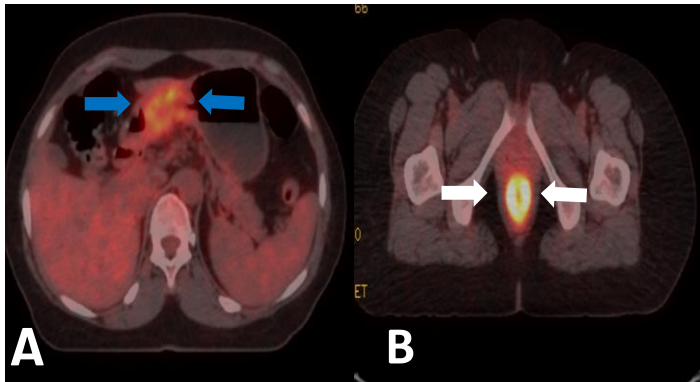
In the PET-CT axial and coronal sections, it is seen that radionuclide material is more intensely uptake in the rectum (white arrow)(B) in the lower pelvic region, as well as the primary tumoral (blue arrow)(A) uptake in the stomach antrum at the upper abdomen level.
